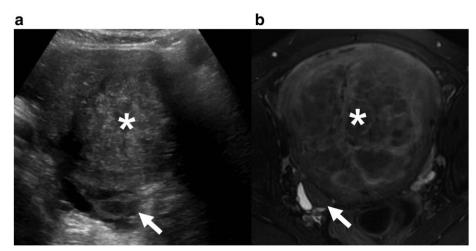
Images from a 43-year-old woman presenting with dysmenorrhea and menorrhagia. (a) Axial view of the uterus from a pelvic US demonstrating a dominant transmural uterine leiomyoma (white asterisk) and a reportedly normal right ovary (white arrow). (b) Axial fat-saturated T<sub>2</sub>-weighted fast spin echo image from a pelvic MRI performed 45 days after the US confirmed the presence of a large fibroid (white asterisk). The MRI also revealed a homogeneously T<sub>2</sub> hypointense lesion (white arrow) arising from the right ovary. The lesion demonstrated corresponding intrinsic T<sub>1</sub> hyperintensity and no enhancement (not shown), consistent with an endometrioma. Dysmenorrhea is more commonly associated with endometriosis rather than fibroids.
